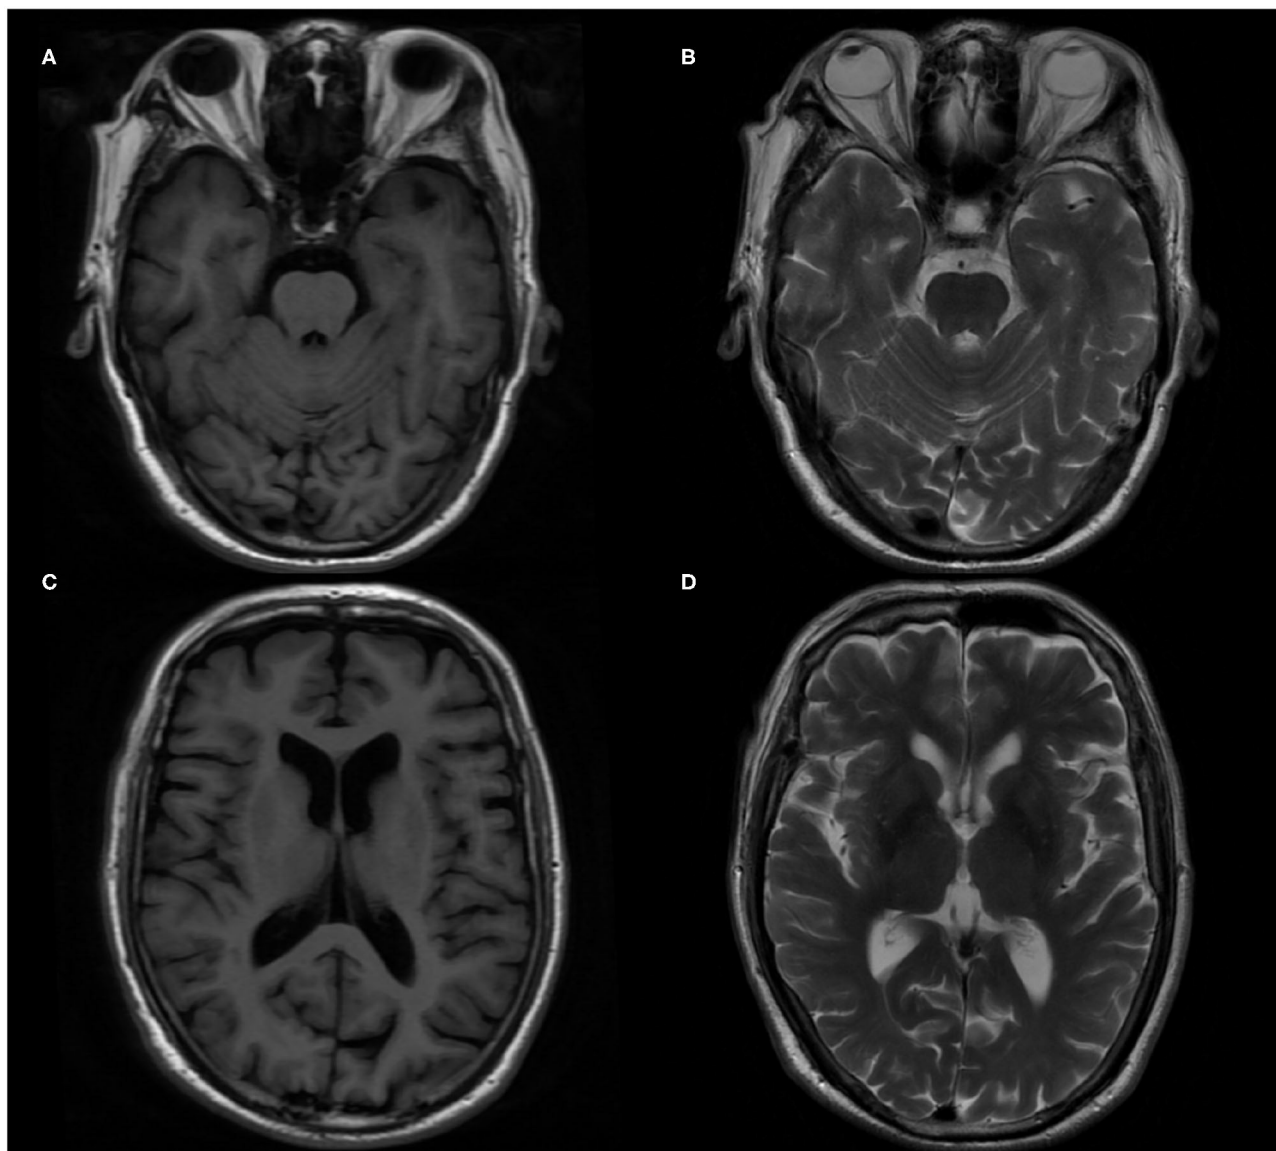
Brain magnetic resonance imaging (MRI) in the patient. (A,C) T1-weighted imaging axial image. (B,D) T2-weighted imaging axial image.
